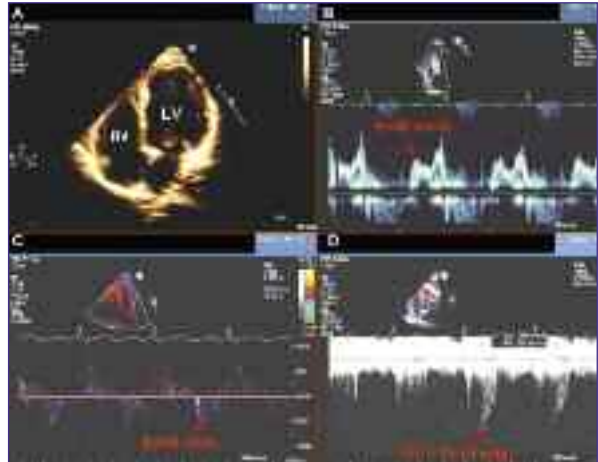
Resting ECHO. This patient is appropriate for DSE: she has normal left ventricular ejection fraction (LVEF = 60%) and E/A = 65/80 = 0.8, consistent with grade I diastolic dysfunction at rest. Normal LV filling pressure is confirmed by E/tissue doppler early diastolic relaxation velocity (E/Ea) = 65/8 = 8. Pulmonary artery systolic pressure at rest is also normal, estimated at 30 mmHg: tricuspid regurgitation (TR) jet = 25 mmHg + 5 mmHg for right atrial pressure estimate.
